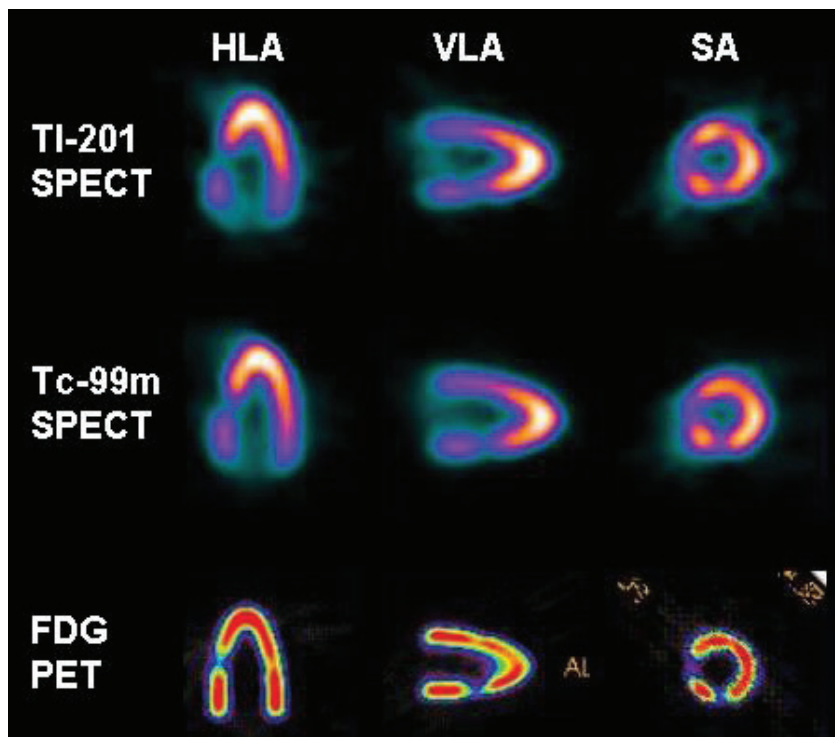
Comparing ^{201}Tl ($t^{1/2}=3$ days) and $^{99\text{m}}\text{Tc}$ ($t^{1/2}=6$ hours) SPECT and ^{18}F FDG ($t^{1/2}=1.8$ hours) PET for myocardial perfusion scan.
